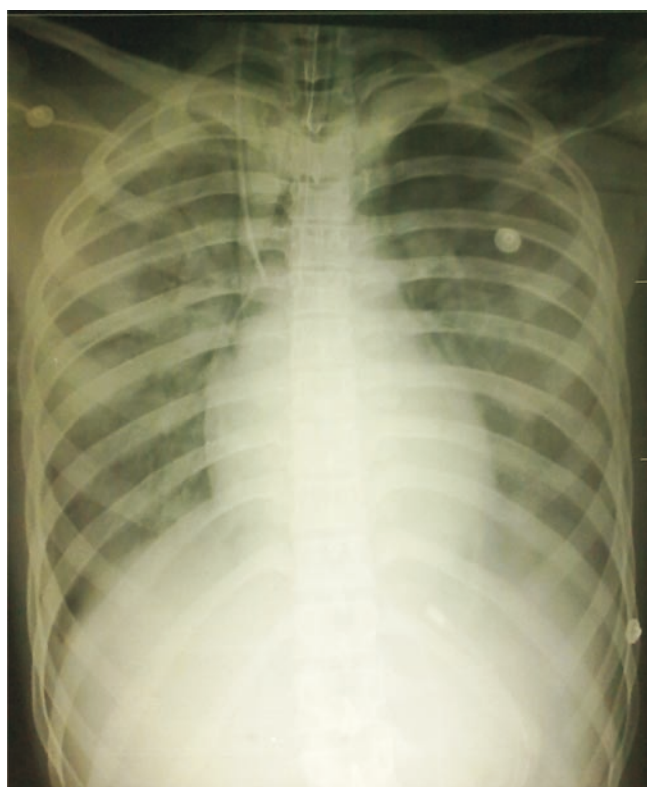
Chest radiograph on day 2 showing clearing of alveolar opacities.
